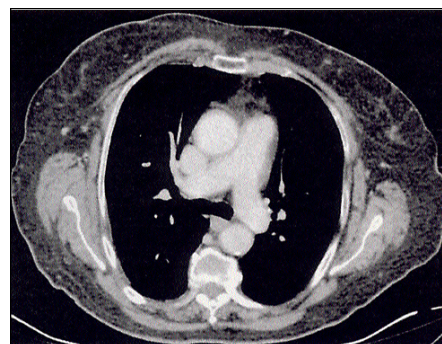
Axial CT scan after iodinated contrast media i.v. administration performed after conservative treatment 5 months later, shows disappearance of mediastinal fluid collection and “restitution ad integrum” of subcutaneous fat of pectoral and sternal regions.
